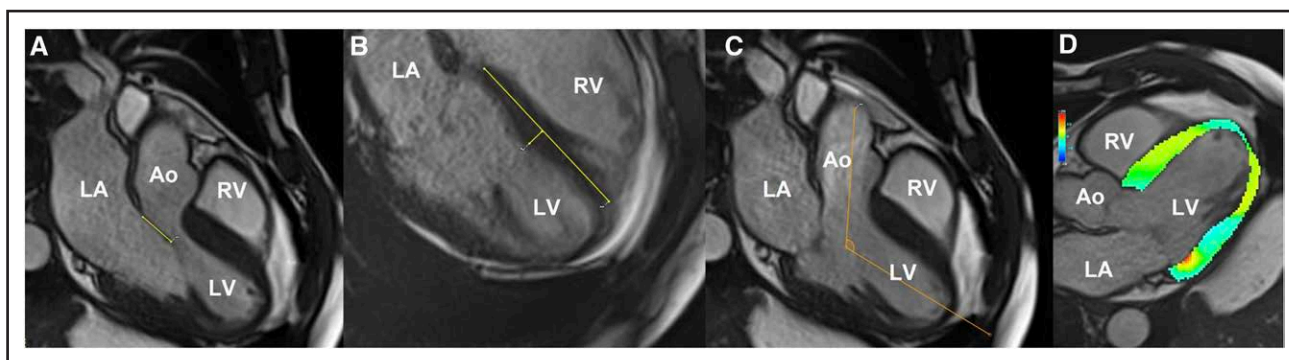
Cardiovascular magnetic resonance imaging.
